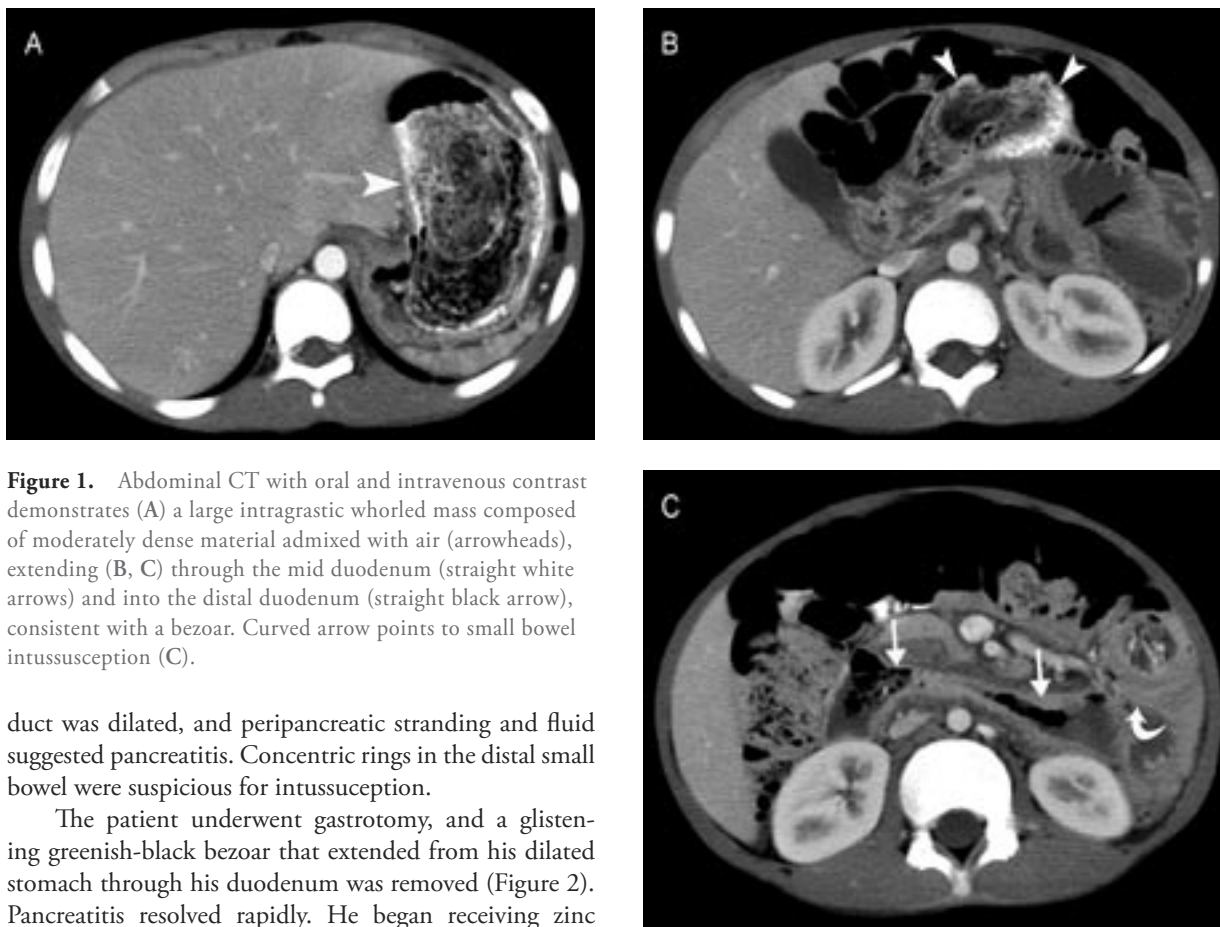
Abdominal CT with oral and intravenous contrast demonstrates (A) a large intragastric whorled mass composed of moderately dense material admixed with air (arrowheads), extending (B, C) through the mid duodenum (straight white arrows) and into the distal duodenum (straight black arrow), consistent with a bezoar. Curved arrow points to small bowel intussusception (C).
